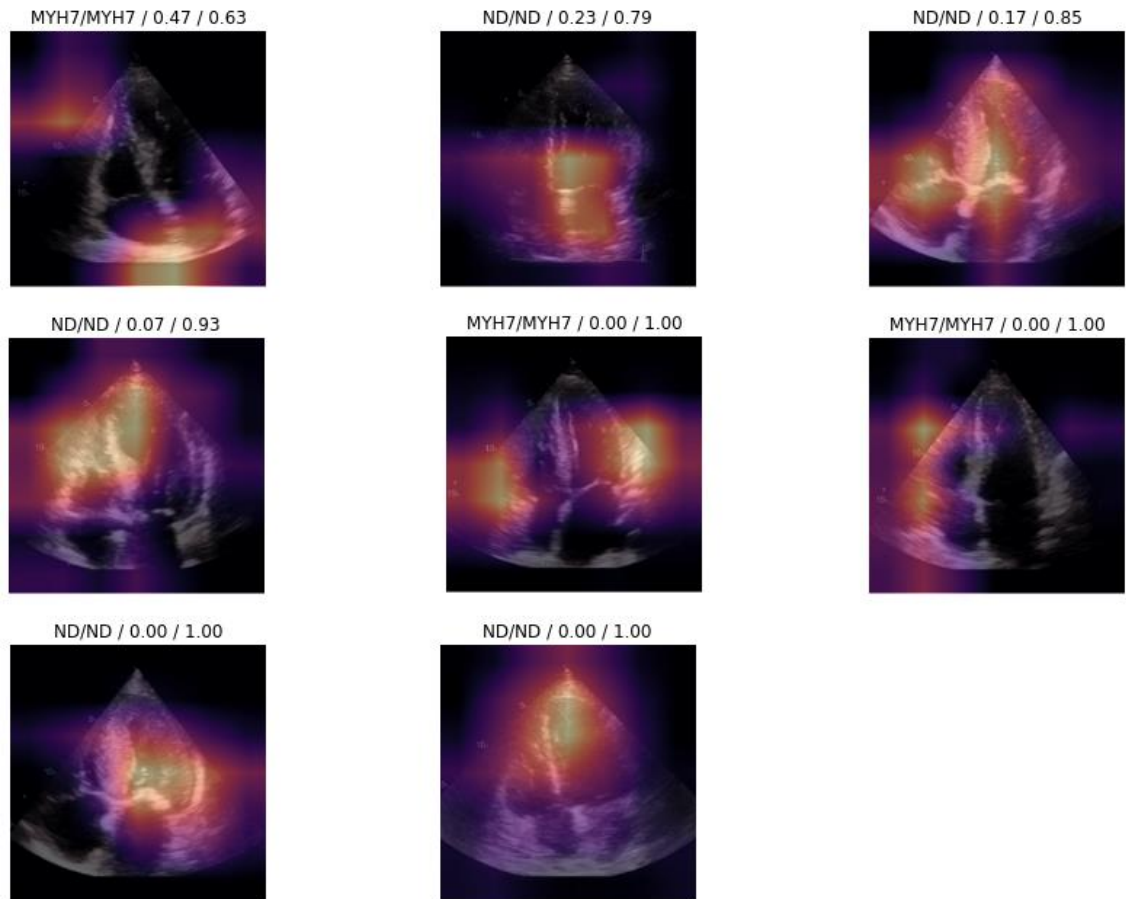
Discriminative areas for classification of a given image (*MYH7* vs. *ND*), apical 4-chamber view during ventricular systole
